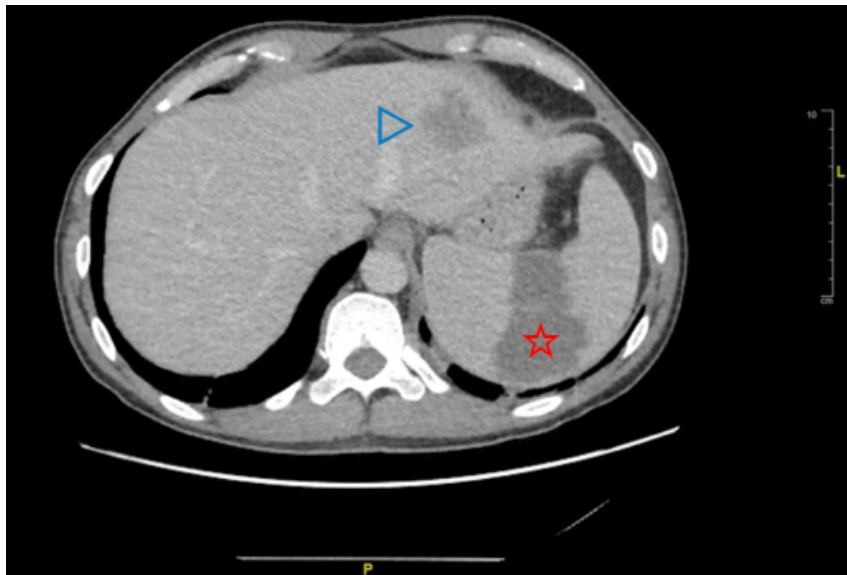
Segmental splenic infarct (red star) and liver hemangioma (blue arrow) seen on CT.
